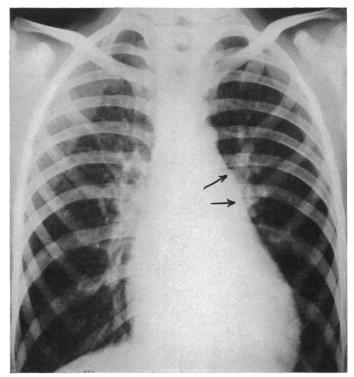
Case 2: Seven-foot roentgenogram prior to operation. Cardiac enlargement, particularly in region of left ventricle. Prominence of pulmonary artery indicated by arrows. Total transverse dimension of heart 11.3 cm. Internal diameter of chest 21.3 cm.
